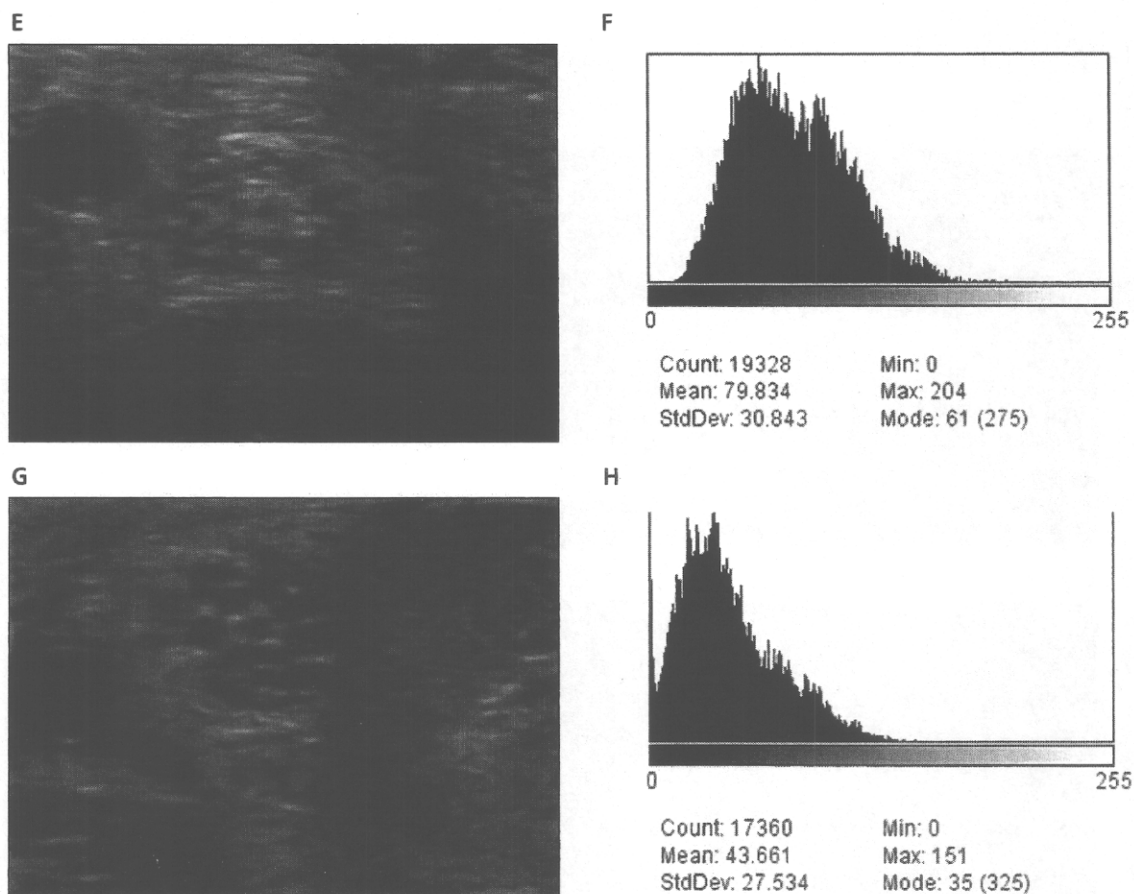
Transverse sonograms and histograms of the nerve at each level. A, Sonogram of the median nerve in a control participant's wrist. B, Histogram of the median nerve in a control participant's wrist. C, Sonogram of the median nerve in a diabetic patient's wrist. D, Histogram of the median nerve in a diabetic patient's wrist (continued).
